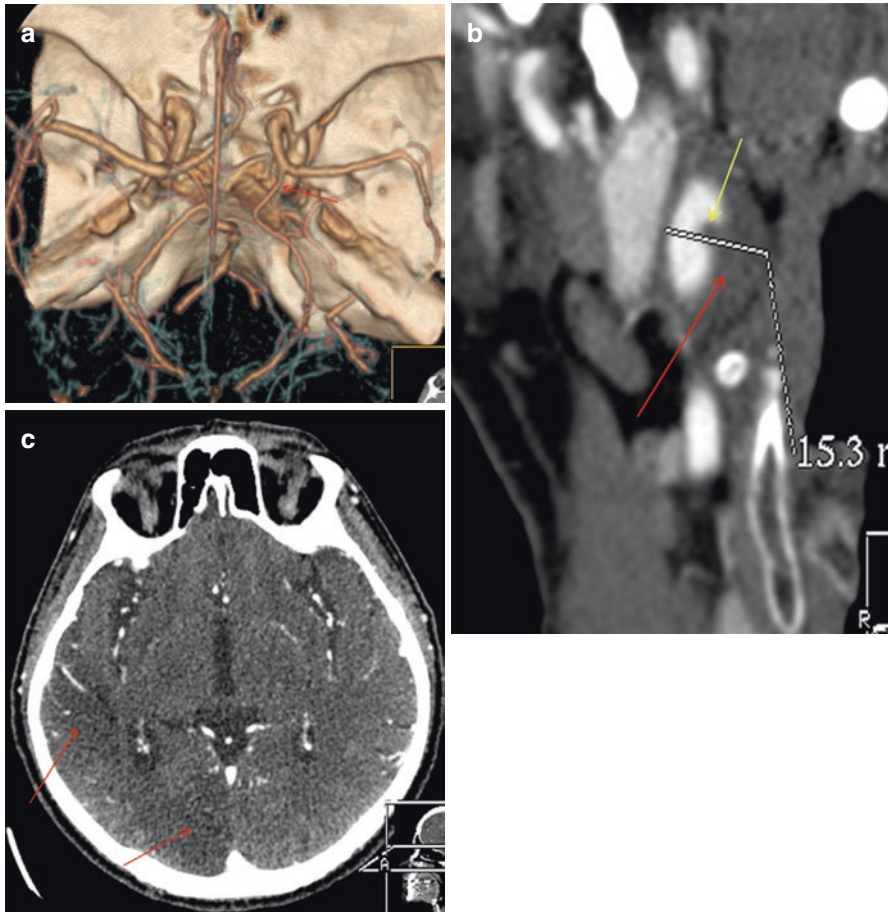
(a) CTA (VRT reconstructions) shows a right sided Fetal Pcom (*red arrow*) (Reproduced from Zampakis et al. [6]). (b) CT oblique MPR image shows increased wall thickness (*red arrow*) and intimal flap (*yellow arrow*) of a dissected right ICA (Reproduced from Zampakis et al. [6]). (c) Axial CT image at the level of 3rd ventricle shows right sided occipital and posterior parietal lobe infarcts (*red arrows*) (Reproduced from Zampakis et al. [6])
